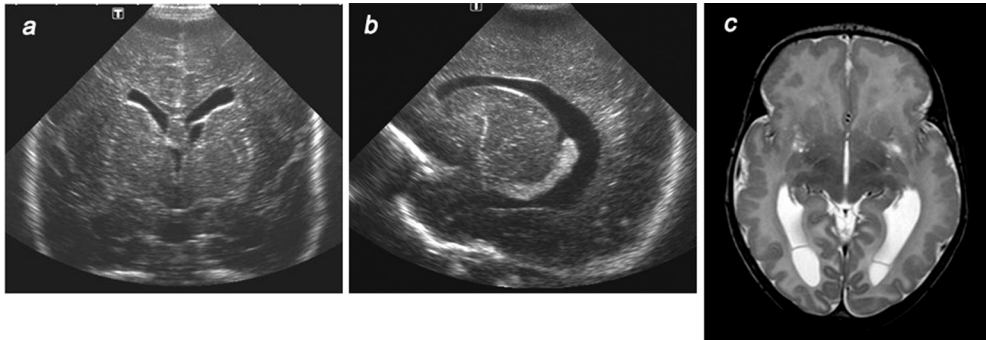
Infant born at term (39+3) with neuro-imaging findings suggestive of a first trimester infection. [A] cUS, coronal view showing a germinolytic cyst on the left and LSV bilaterally; [B] cUS, sagittal view showing LSV; [C] a T2-weighted MRI, axial view, additionally showing occipital cysts and extensive bilateral polymicrogyria.
